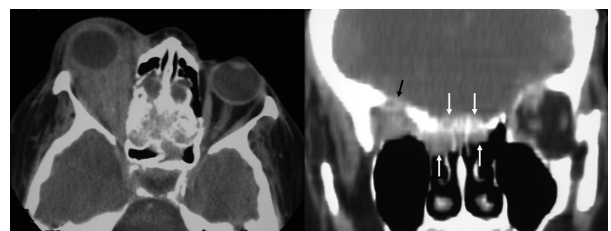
Axial and coronal CT. Bone erosion is present along the right orbital roof (black arrow) and infiltration of the skull base and ethmoid sinuses (white arrows).
